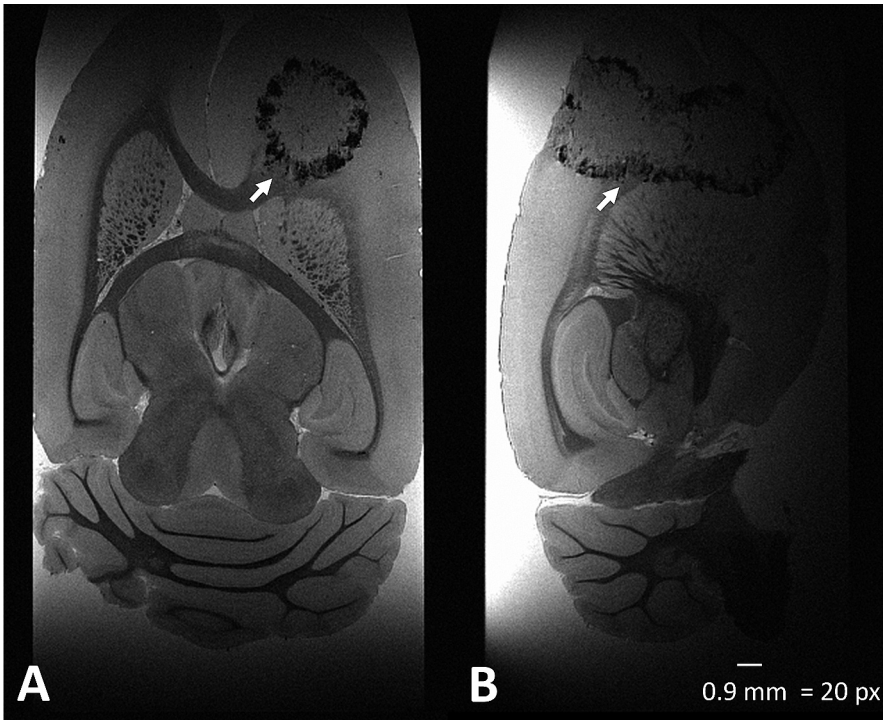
T2*-weighted 3D MRI at a resolution of 45 micros of a fixed brain 14 days of inoculation of 5000 cells in axial (A) and sagittal (B) view. Arrows indicate infiltration along the corpus callosum. The intensity gradient reflects the sensitivity of the cryocoil.
